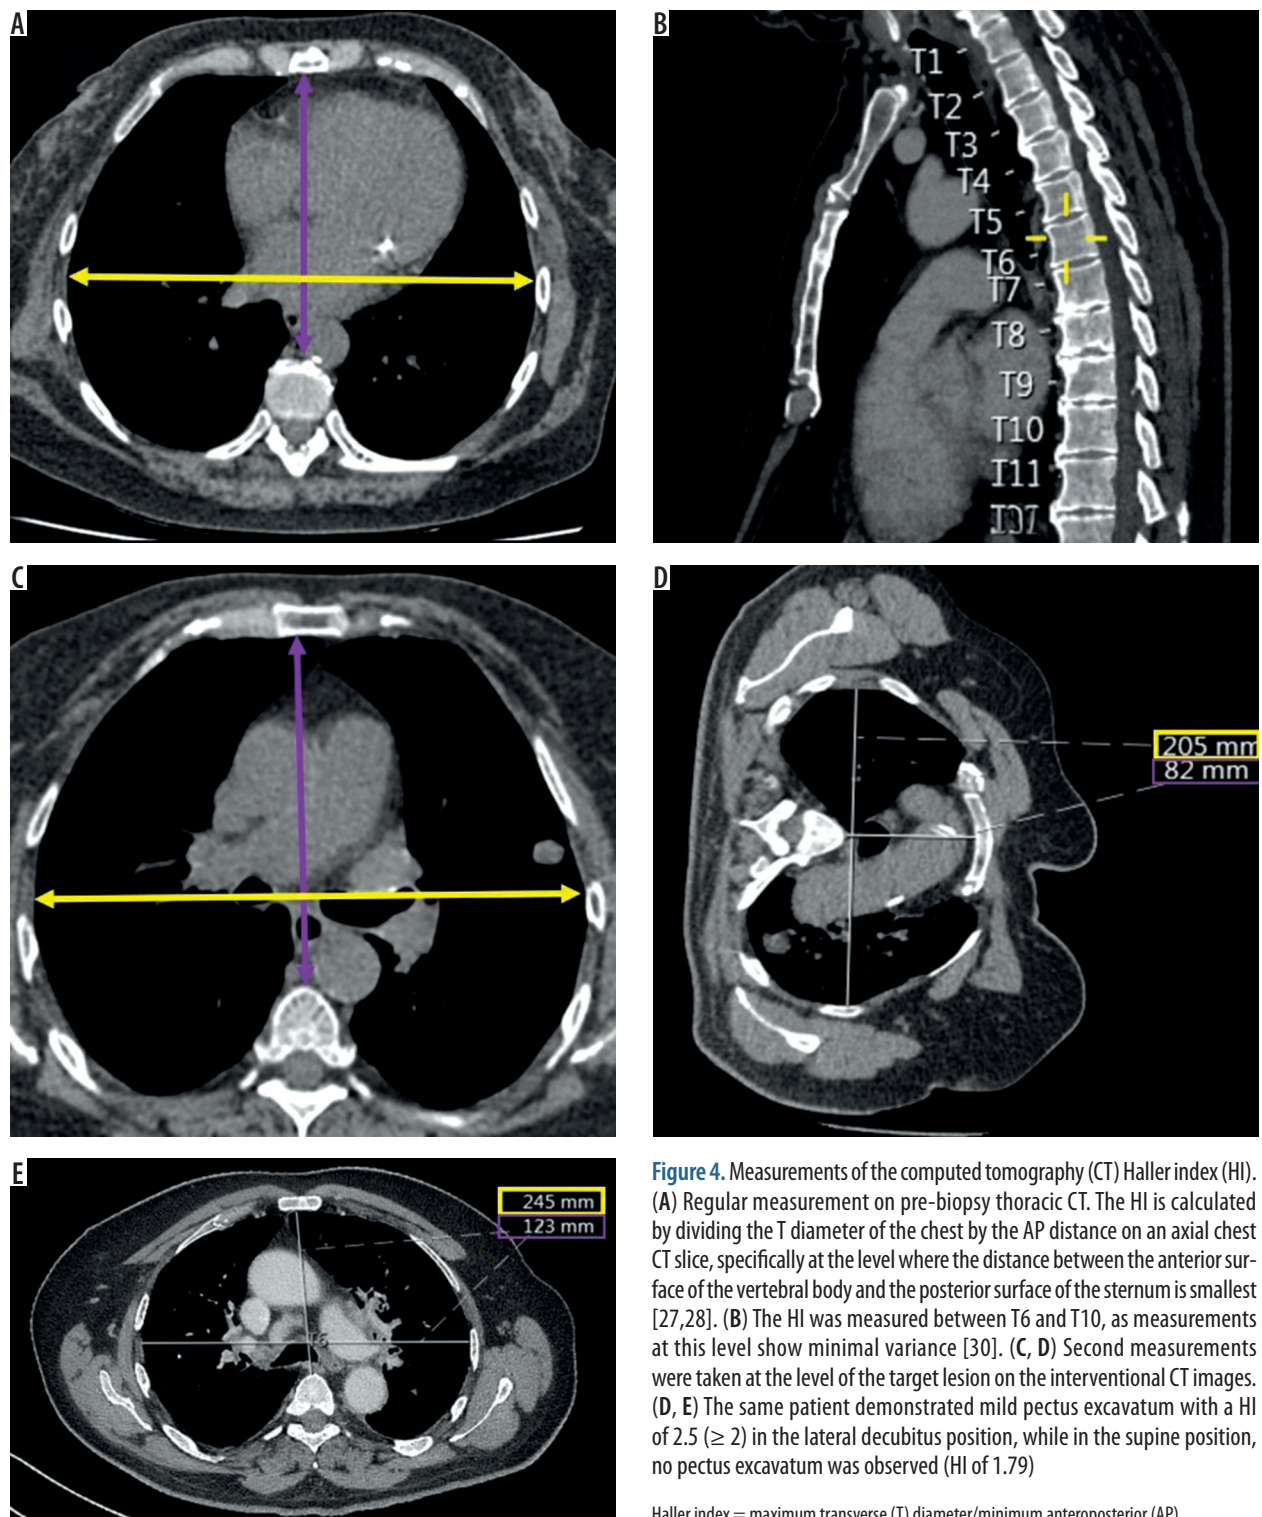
Measurements of the computed tomography (CT) Haller index (HI). (A) Regular measurement on pre-biopsy thoracic CT. The HI is calculated by dividing the T diameter of the chest by the AP distance on an axial chest CT slice, specifically at the level where the distance between the anterior surface of the vertebral body and the posterior surface of the sternum is smallest [27,28]. (B) The HI was measured between T6 and T10, as measurements at this level show minimal variance [30]. (C, D) Second measurements were taken at the level of the target lesion on the interventional CT images. (D, E) The same patient demonstrated mild pectus excavatum with a HI of 2.5 (≥ 2) in the lateral decubitus position, while in the supine position, no pectus excavatum was observed (HI of 1.79)
